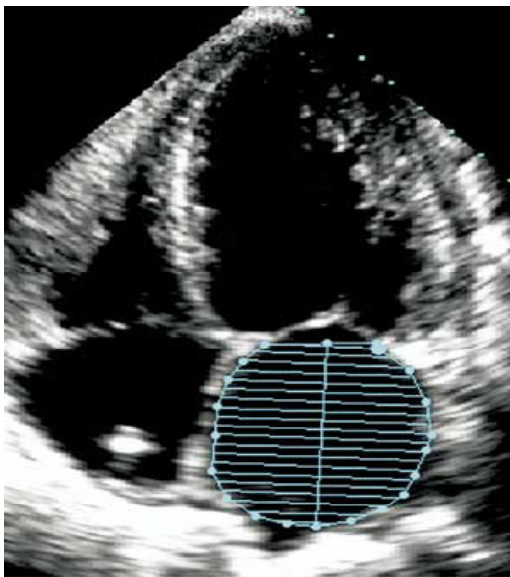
Measurement of left atrial (LA) volume from biplane method of discs (modified Simpson’s rule) using apical 4-chamber (left) and apical 2-chamber (right) views at ventricular end systole (maximum LA size).
